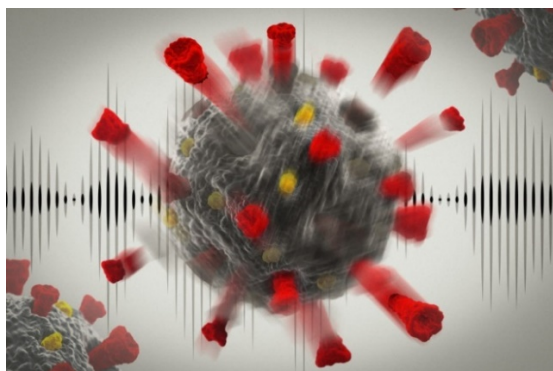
Ultrasound has potential to damage coronaviruses
